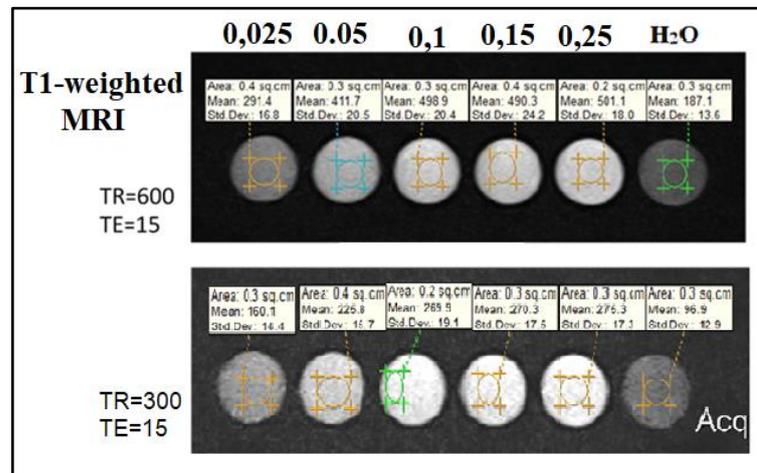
MRI images using different concentrations in TE = 15 TR = 300 and TE = 15 TR = 600 imaging modes.
